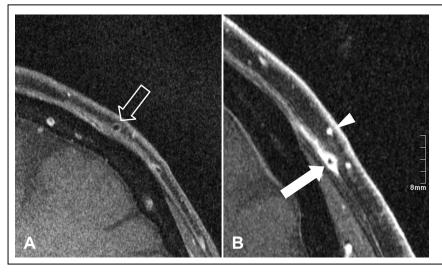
Post contrast MRI in two patients at 3 Tesla.
